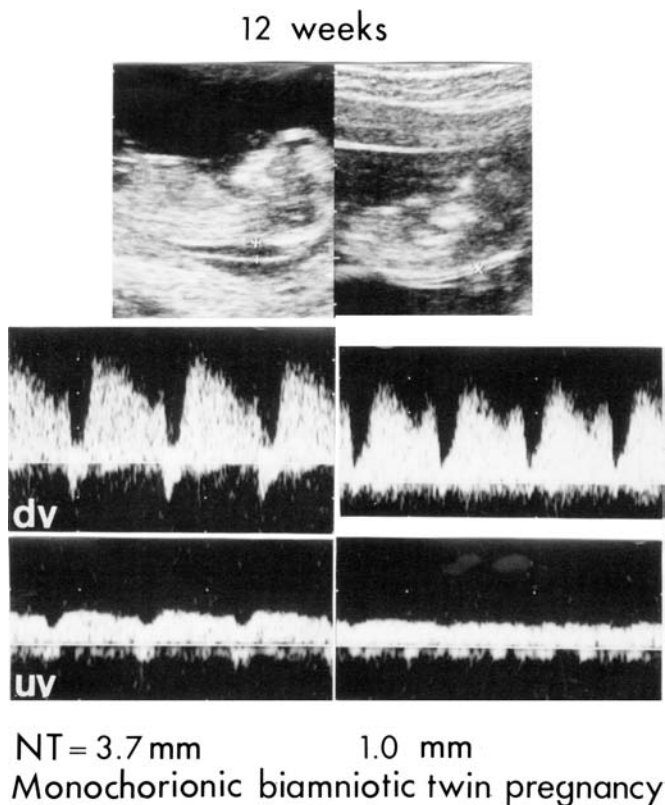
A monozygotic diamniotic twin pregnancy was established at 12 weeks of gestation. Doppler blood flow waveforms in both fetuses were obtained in the umbilical vein (UV) and ductus venosus (DV) in the same scan. A nuchal translucency (NT) discrepancy was noted (NT=3.7/1.0 mm). The fetus with increased nuchal translucency shows an inverted A-wave in the DV and dirotic pulsatile flow in the UV. TTTS developed at 17 weeks and the patient was referred for laser ablation of anastomosis.
